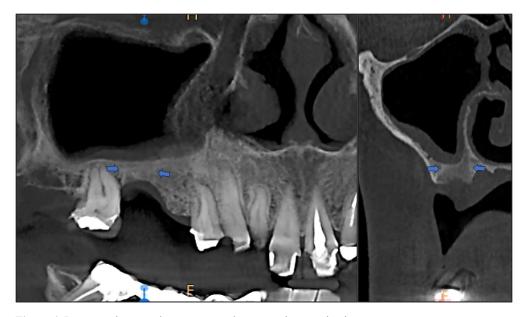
Postoperative cone-beam computed tomography examination. Successful healing and closure of the sinus (blue arrows).
